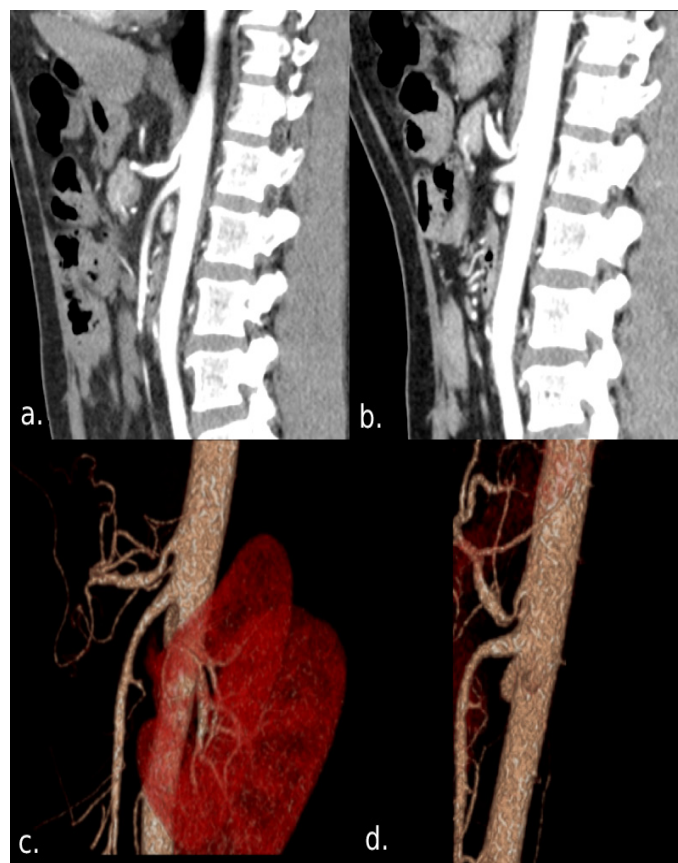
Contrasted sagittal reconstruction of the celiac trunk (CTA) and in 3D, in deep inspiration (a) and forced expiration (b), in (b) and (d) narrowing or imprinting of the celiac trunk secondary to the median arcuate ligament is observed, configuring the origin of the celiac trunk hooked appearance with post-stenotic dilatation. No signs of atherosclerosis or signs of arteriosclerotic disease were observed.
